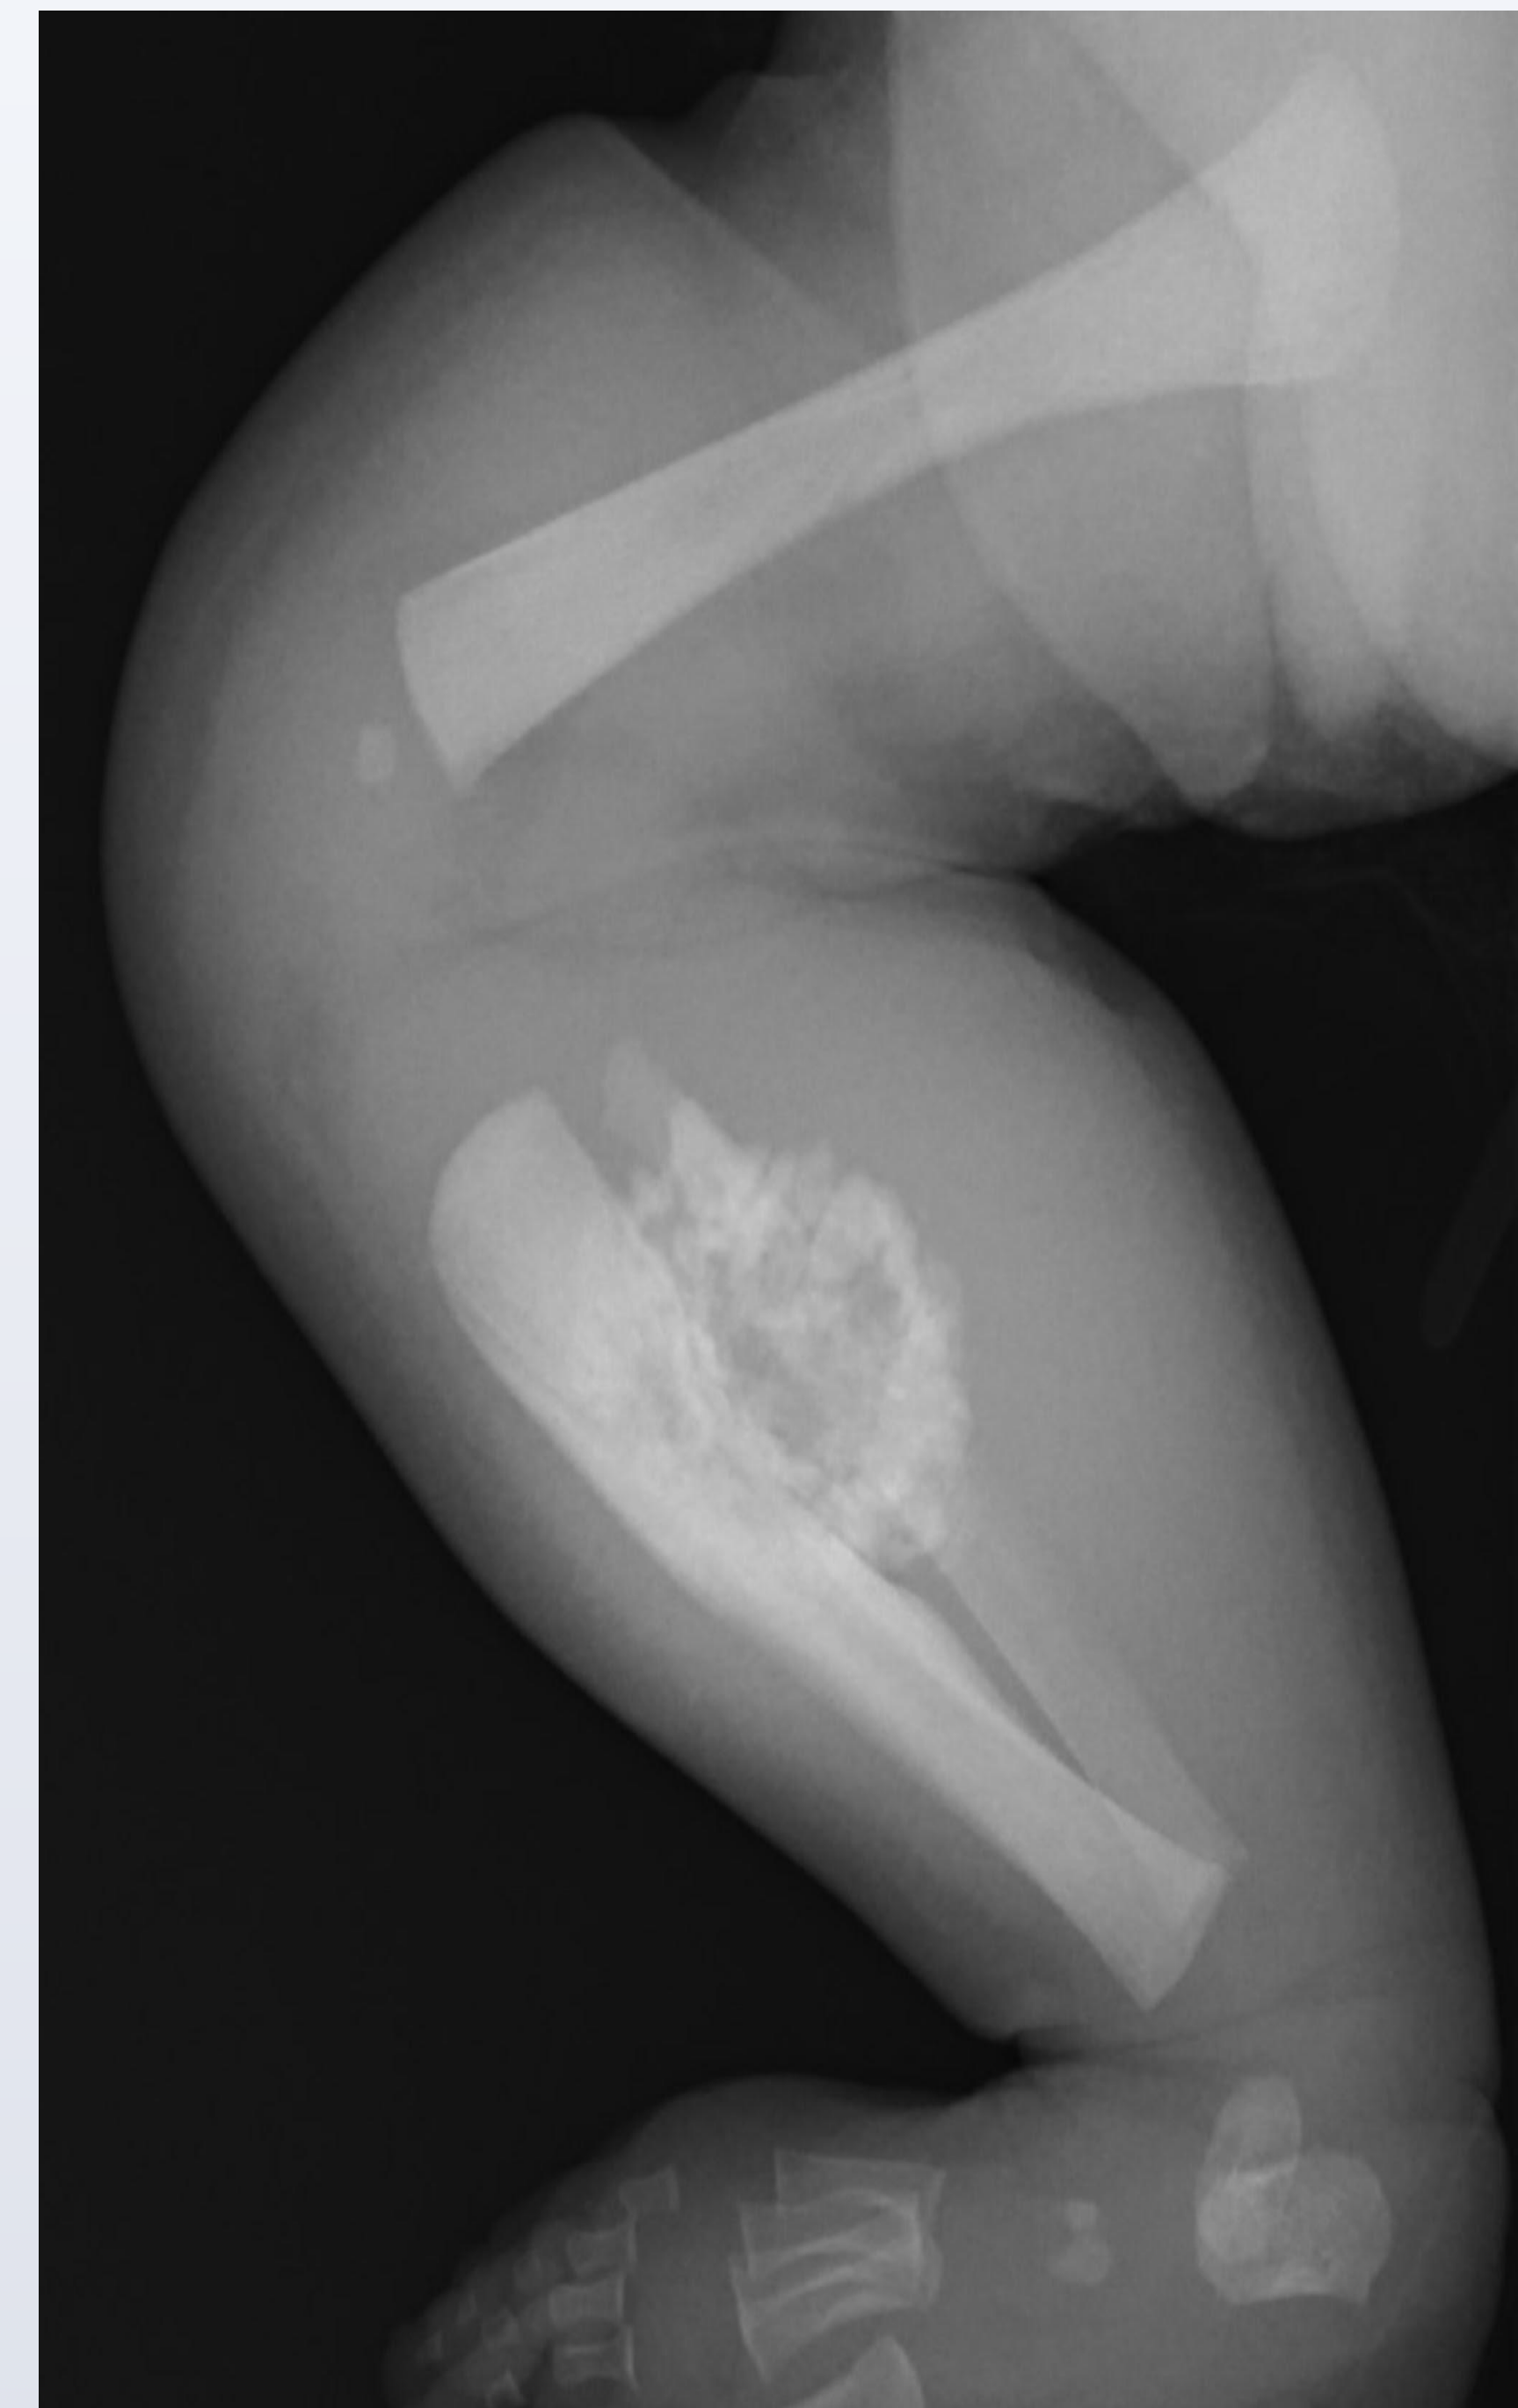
Frog-leg view radiograph of the right leg demonstrating an aggressive, expansile calcified mass in the posterior cortex of the proximal mid tibial diaphysis with cortical scalloping
